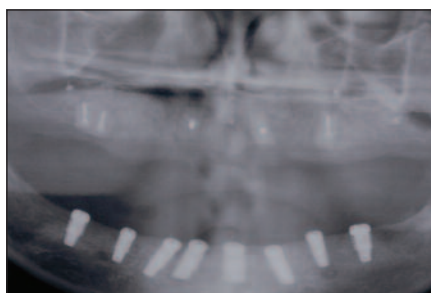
Panoramic radiograph showing the fixation screws for all of the block grafts placed. The mandibular 8 implants (BioHorizons) had been placed already.
